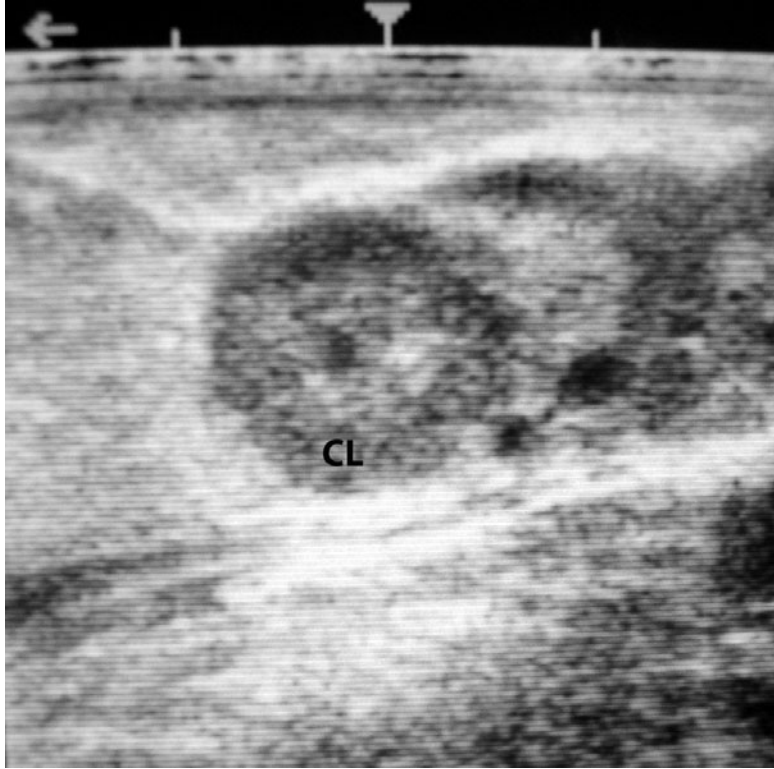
Ultrasonogram of a mature corpus luteum. Note the size and the small central cavity.
